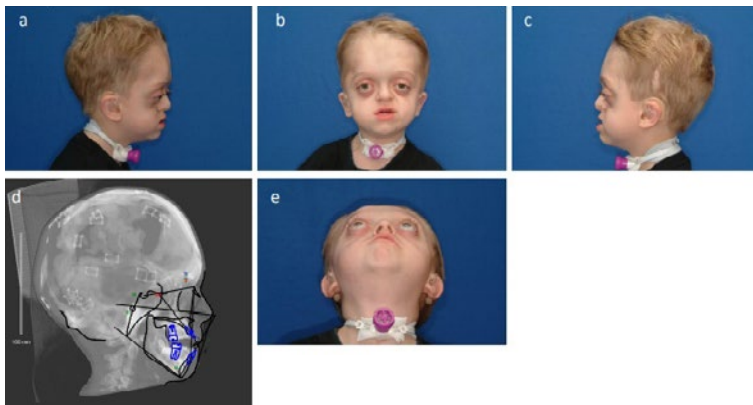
Case 1 - 5-year-old male with Crouzon syndrome. (a, b, c, e) Initial facial photographs and (d) lateral cephalometric radiographs.
